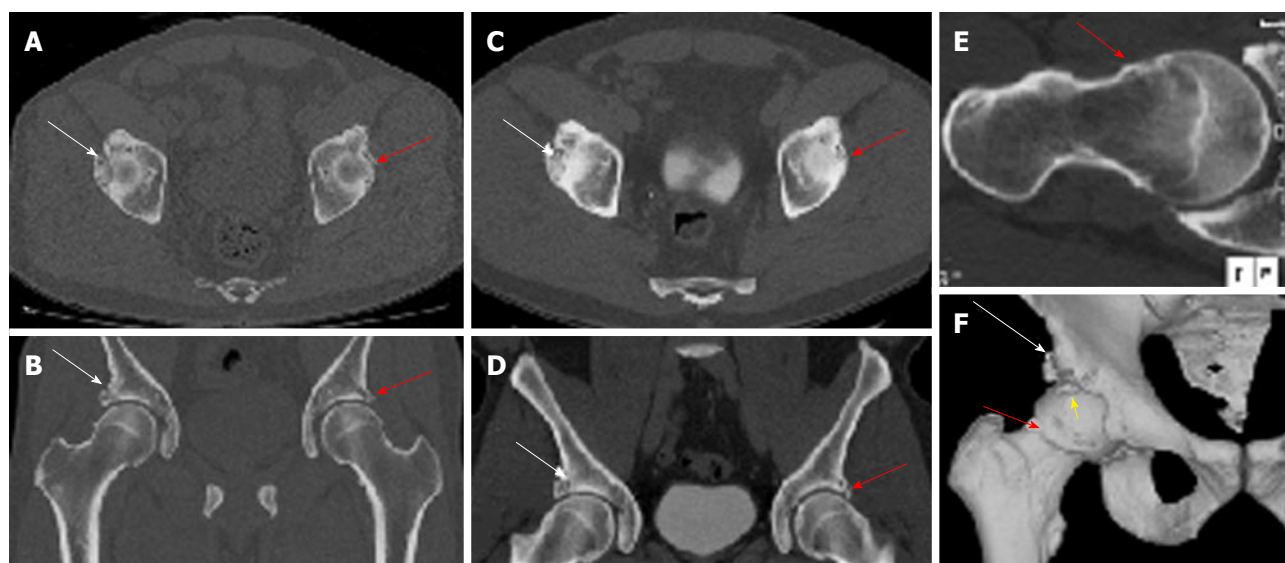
3D computed tomography imaging of the pelvis. Computed tomography pelvis obtained at current presentation (A, B) and 2 years before (C, D) confirm the unchanged bilateral mixed femoroacetabular impingement anatomy with a chronic right acetabular rim fracture (white arrows) and small left Os acetabulum/labral calcification (yellow arrow). Oblique axial thick slab maximum intensity projection reconstruction (E) along the right femoral neck axis shows the CAM deformity (red arrow) and fibrocystic change at the head and neck junction. Surface rendered 3D bone reconstruction (F) confirms the rim fracture (white arrows) and the CAM deformity (red arrow). Also note loose fragment anteriorly and superiorly, which was subsequently removed on surgery (yellow arrow).
